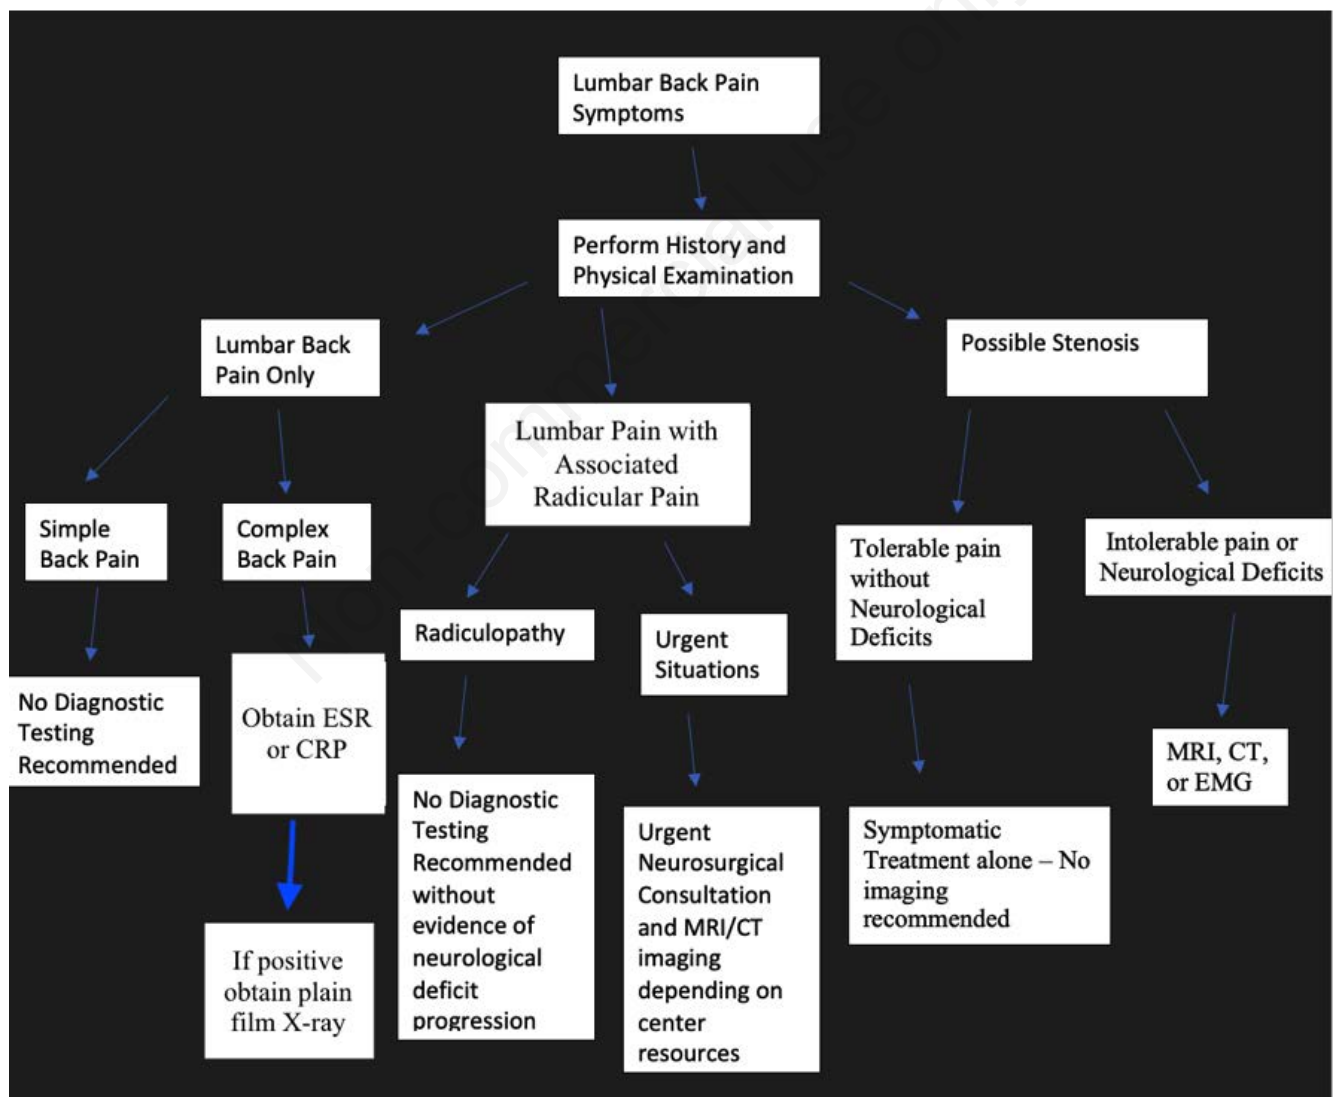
ESR: Erythrocyte Sediment Rate, CRP: C-Reactive Protein CT: computerized tomography; MRI: magnetic resonance imaging, EMG: Electromyography. Detailed here is a diagnostic decision tree based on data from several peer reviewed studies and literature reviews.⁹⁻¹⁵
